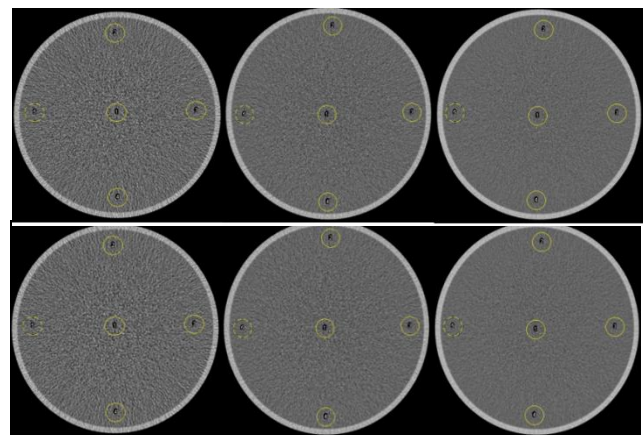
Measurement of CT number with five ROIs
